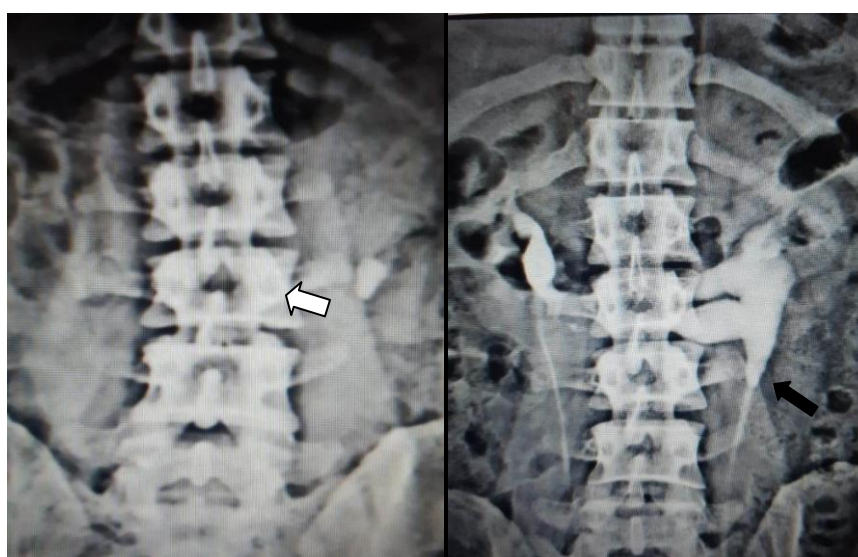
A. Plain radiograph KUB region showing calculus in left renal region (white bold arrow). B. IVU showing calculus impacted at left PUJ (black bold arrow) with moderate hydronephrosis
